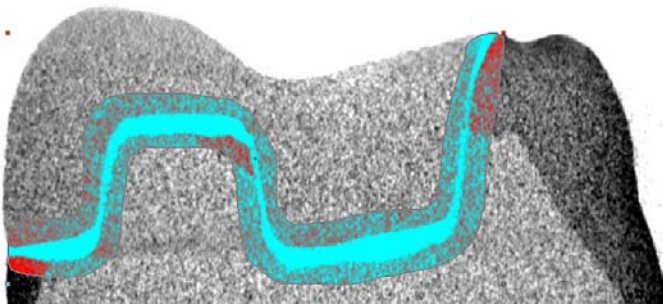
The designated area for the three dimensional reconstruction of internal gap on a CT file.
